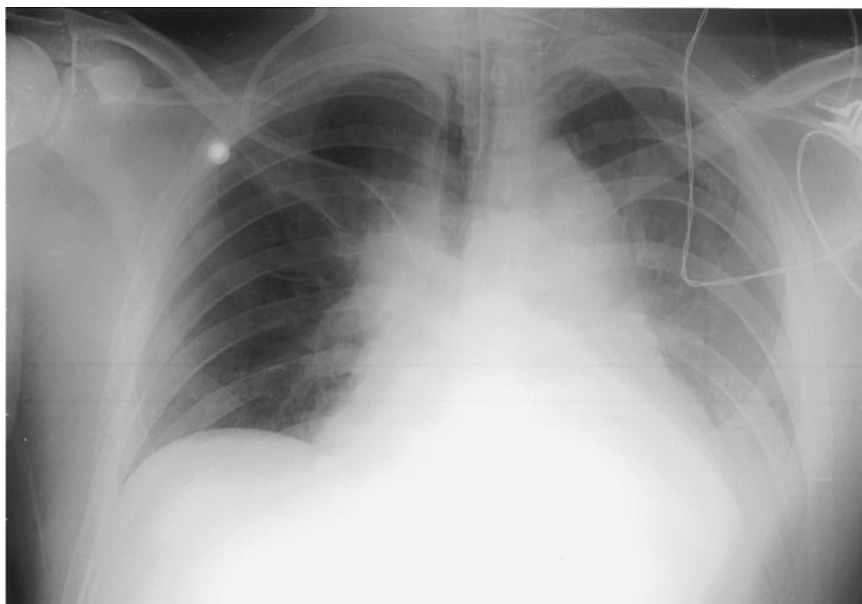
Plain chest x-ray exhibiting many features of acute type A dissection, such as a widened mediastinum, rightward tracheal displacement, irregular aortic contour with loss of the aortic knob, an indistinct aortopulmonary window, and a left pleural effusion.
